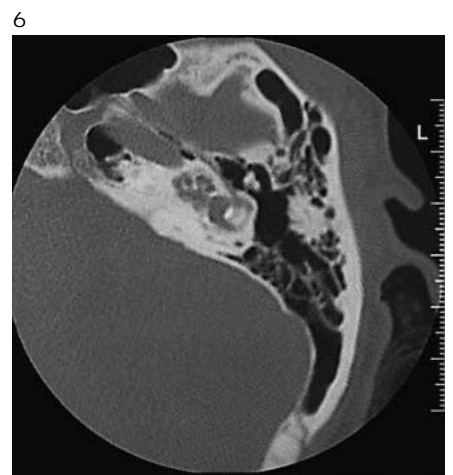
High-resolution CT scan of both petrous bones shows demineralization in both labyrinthine capsules with irregular margins of the cochlea and to a smaller extent around the vestibule.
